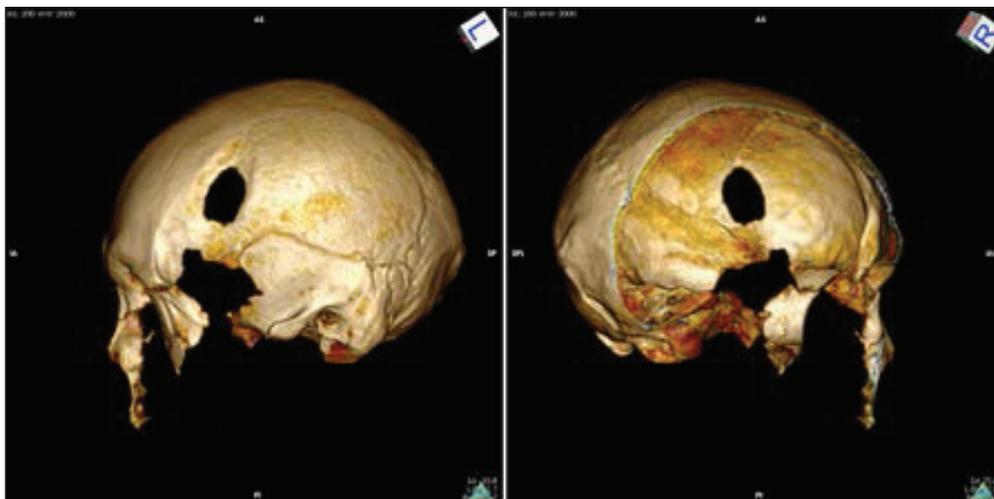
CT scan of the cranium. View of the trepanned aperture from the ectocranial and endocranial side.
